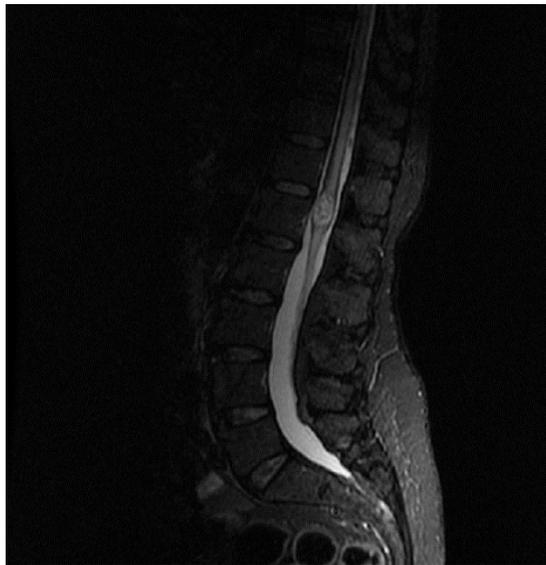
T2-weighted MRI image showing intraspinal metastasis of breast cancer to the spinal cord at Th12-L1 level – sagittal view
